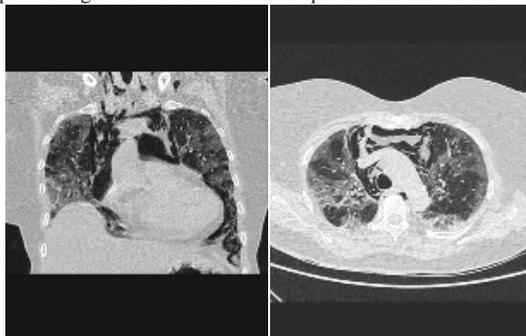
Imaging showing pneumomediastinum and its resolution. Coronal CT
